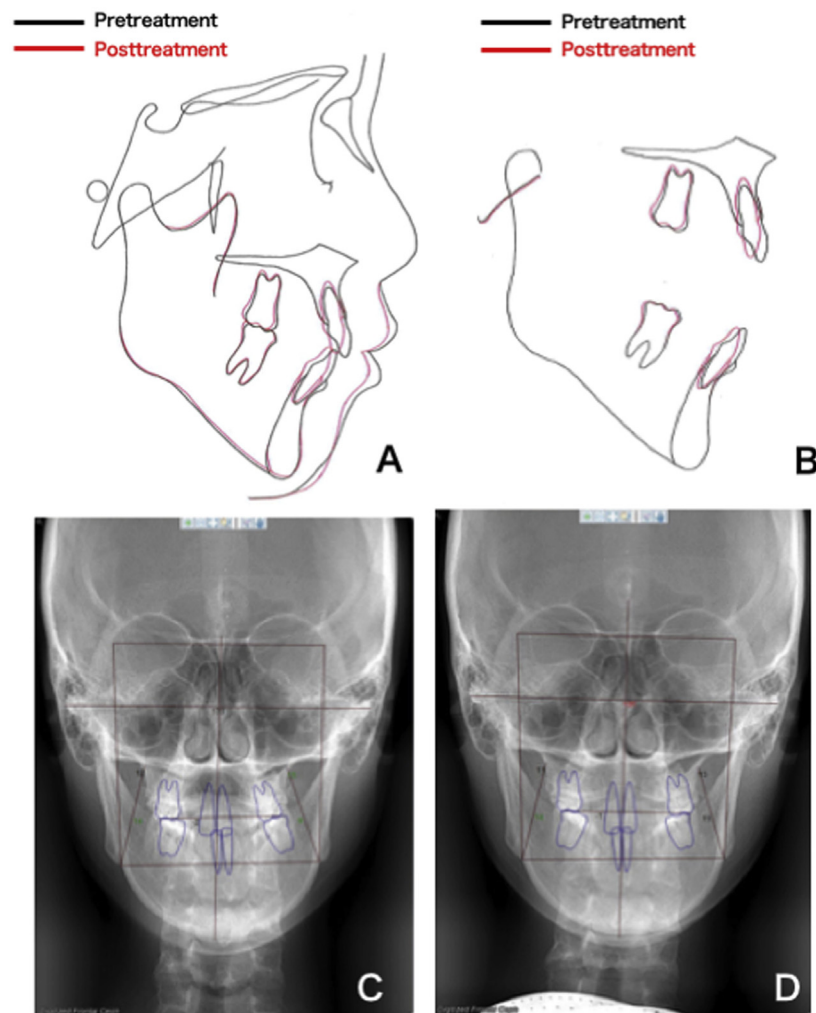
Patient 2: A and B, pretreatment and posttreatment cranial and regional superimpositions; C and D, pretreatment and posttreatment PA radiographs. Correction of the midline deviation is indicated in the PA radiograph.
